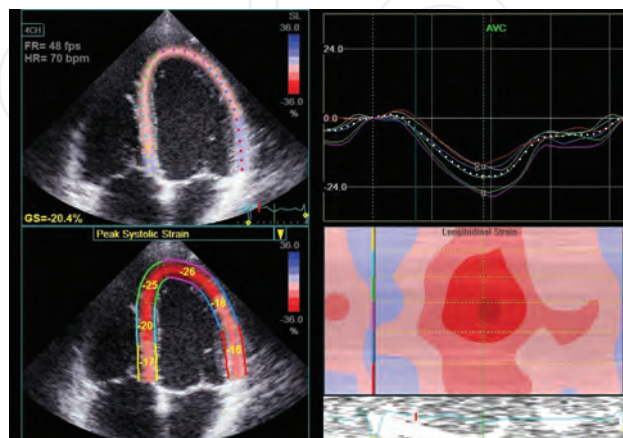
Strain analysis from two-dimensional speckle tracking from apical four chamber view.
